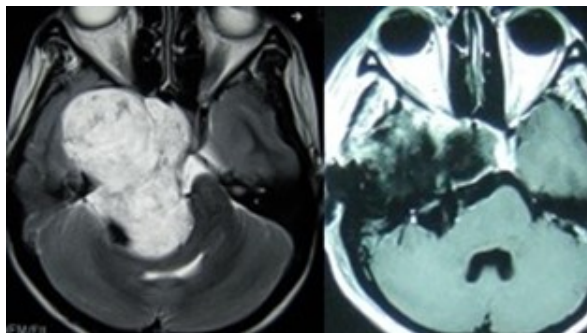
Contrast MRI of brain showing preoperative image of right trigeminal schwannoma occupying both middle and posterior cranial fossa on left-hand side and postoperative image of the same case on right-hand side. Source: Figure by authors.
